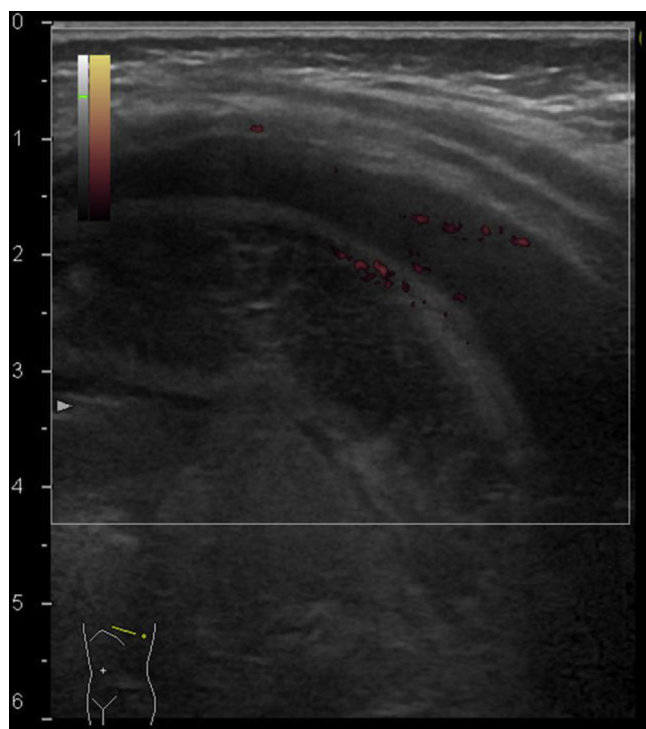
The ultrasonographic appearances immediately after arrival to the emergency department. Ultrasonographic examination shows an edematous wall-thickened jejunum surrounded with pleural effusion. Jejunal blood flow was impossible to confirm on power Doppler evaluation.
